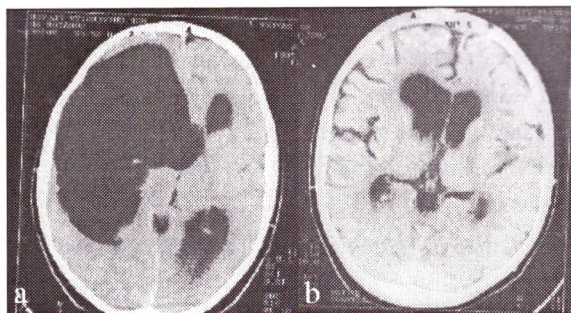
CT scans of a patient with porencephalic cyst before /a/ and 3 months after /b/ the operation.
